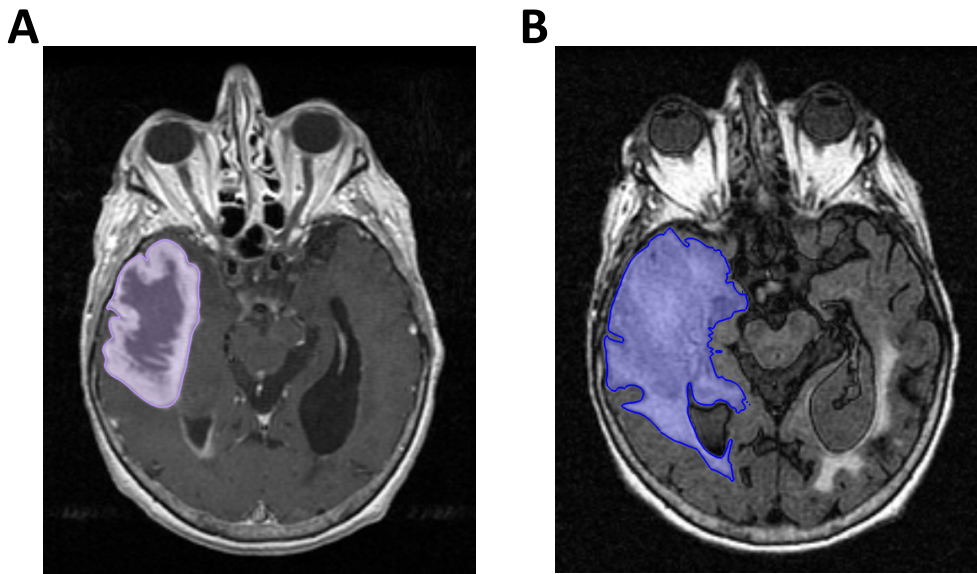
Binary mask segmentation for a 60 year old male patient with a right temporal GBM. Masks were manually drawn in Velocity A1 using the 2D flood fill tool (Purple, blue areas) to cover tumor volumes on (A) Post Gd images and (B) FLAIR images. Note that the FLAIR “envelope” includes both edema (hyper intense signal) as well as the tumor itself, minus the area occupied by the ventricles.
